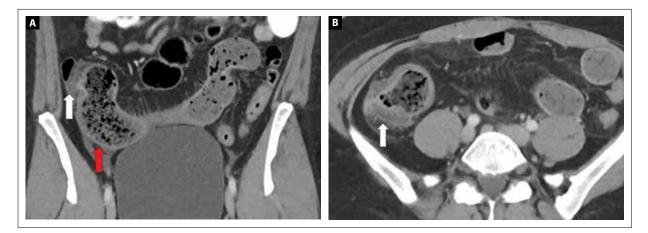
Coronal (A) and axial (B) images from dual-source, dual-energy abdominopelvic computed tomography performed with intravenous and oral contrast showing terminal ileum narrowing (white arrow in each image) with upstream small bowel dilation up to 4.8 cm, compatible with stricture. The upstream dilated small bowel shows small bowel feces sign and pseudosacculation along the antimesenteric border (red arrow in A), a finding of chronicity. However, iodine density analysis showed iodine density of 4.0 mg/mL and 55.1% aorta enhancement within the stricture, findings compatible with active inflammation despite the 83.8 Hounsfield unit measurement, which does not meet the threshold for active inflammation. This stricture was new from the study performed 8 months prior and demonstrated severe active inflammation on ileocolic resection, which was confidently diagnosed preoperatively using dual-energy computed tomography iodine density analysis.
